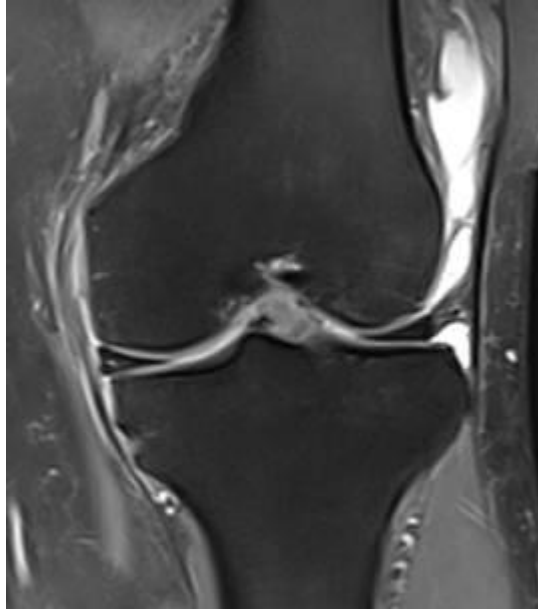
Image B-1 MRI coronal PD image for Left knee of male 37 years old showed medial meniscus tear grade I
